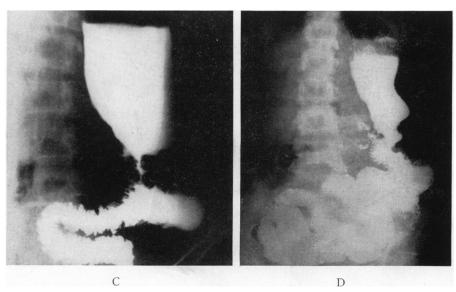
(C) Barium meal 11 days after a reconstructive operation on the stoma reducing its size to 2½ cms. Lateral x-ray 5 minutes after the meal.
